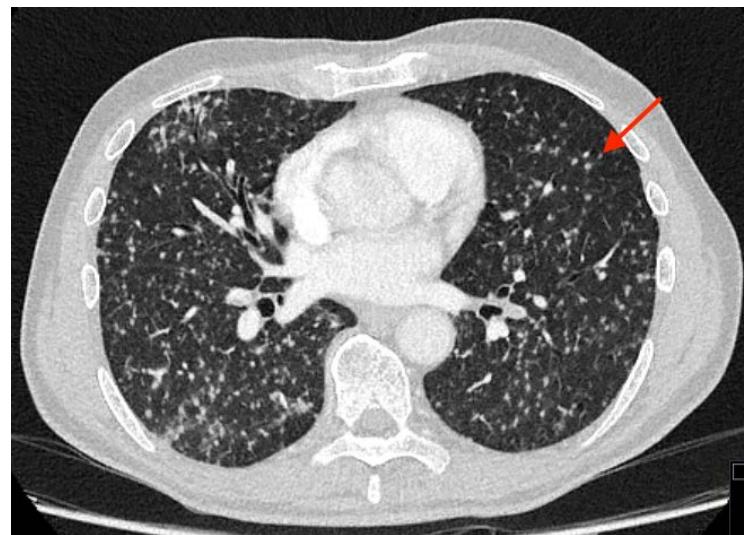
71-year-old male with disseminated tuberculosis following BCG therapy. FINDINGS: Axial chest CT shows numerous <2 mm randomly distributed nodules (arrow) involving both lungs concordant with miliary tuberculosis. TECHNIQUE: Axial contrast-enhanced chest CT using 120 kV, 180 mAs, 1.0 mm slice thickness, 100 mL iodinated contrast medium during venous phase.
